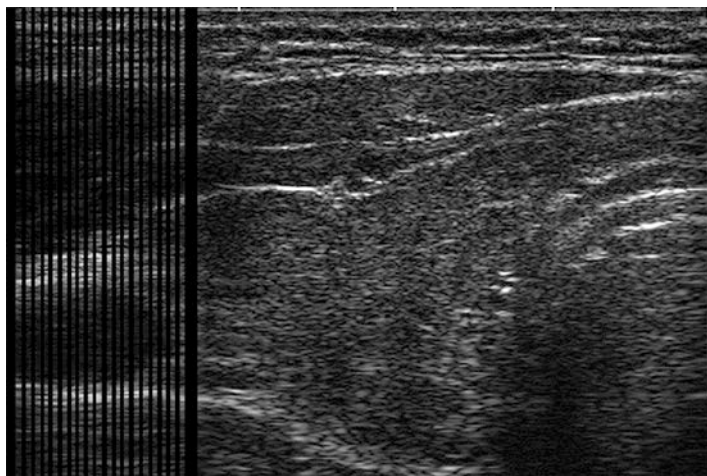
A B-mode ultrasound image is composed of a series of A-mode images aligned to provide a two-dimensional image
